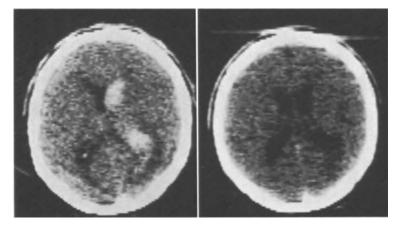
Left: CT: Blood clots in the right lateral ventricle in a 47-year-old man. No operation. *Right:* CT of the same patient 18 days later: Resorption of the clot. The patient survived with hemianopia
